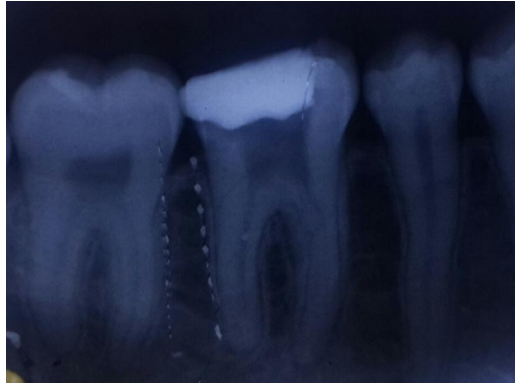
Radiograph showing the broken file was bypassed using no:15 K file
